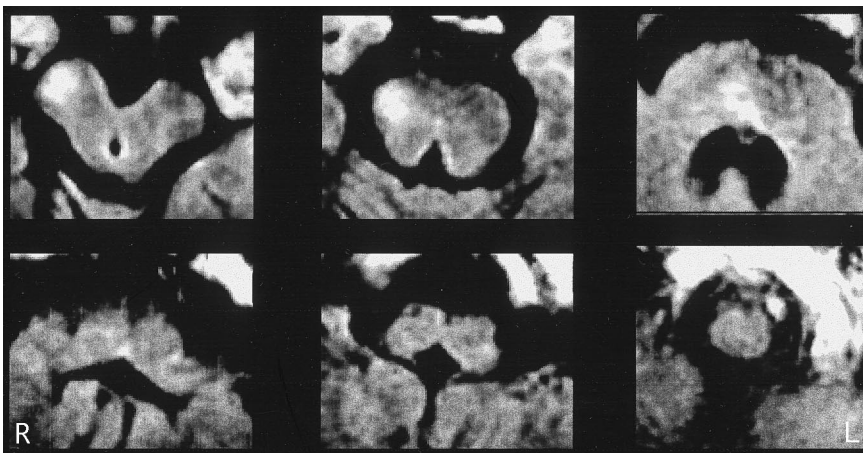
Fluid-attenuated inversion recovery MRI 10 months after onset. High-intensity lesions are visible in the right cerebral peduncle, pontine base, and medulla, corresponding to the location of the pyramidal tract. Note the shape of the medulla, which appeared to be separated in the midline, and the cervical cord, which was normal in shape.
